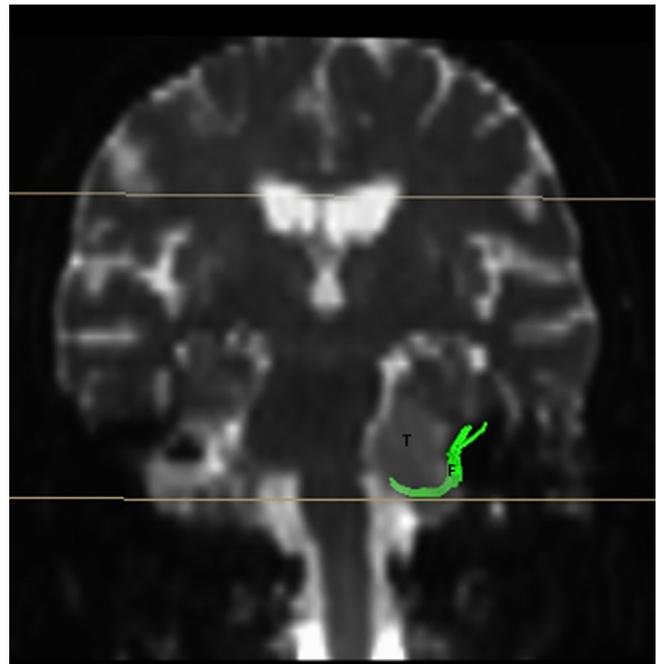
Coronal T2-weighted MR image: DTT revealing the course of facial nerve, inferior to the tumor (green line). T: Tumor, F: Facial.
